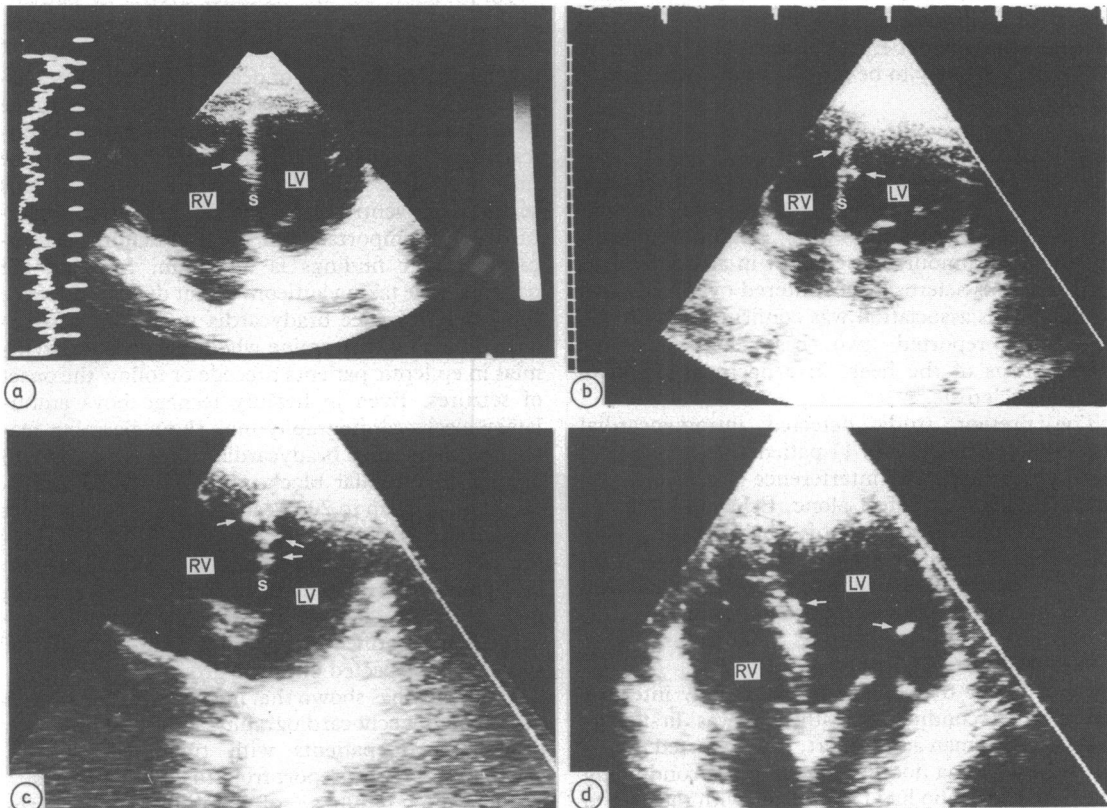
Figure Examples of echocardiographic abnormalities in patients with tuberous sclerosis. Intramyocardial masses (arrowed) were detected as single (a) or multiple (b, c) lesions in the ventricular septum and were also seen in the posterior left ventricular wall (d). RV, right ventricle; LV, left ventricle; S, ventricular septum.
